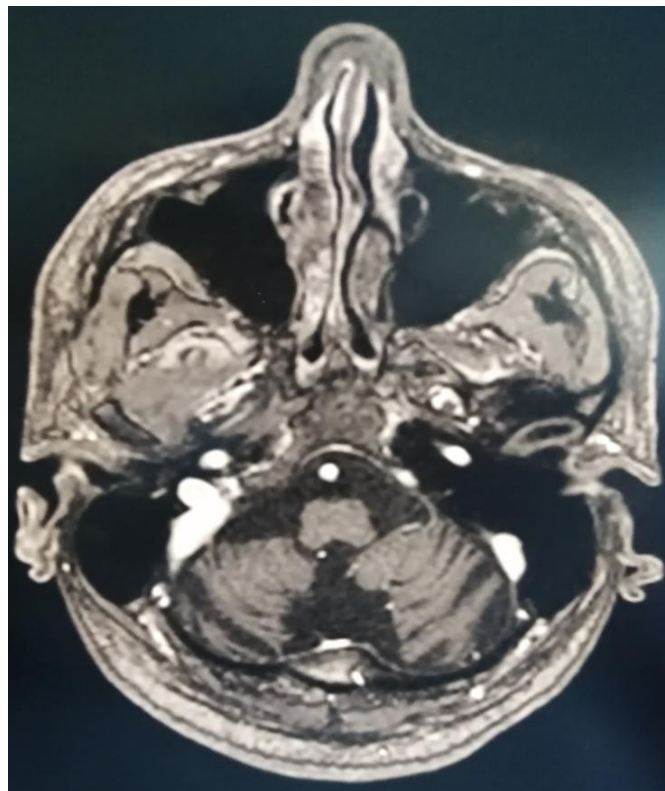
Cerebral Magnetic Resonance Imaging (MRI) in axial section showing vermial and cerebellar atrophy
